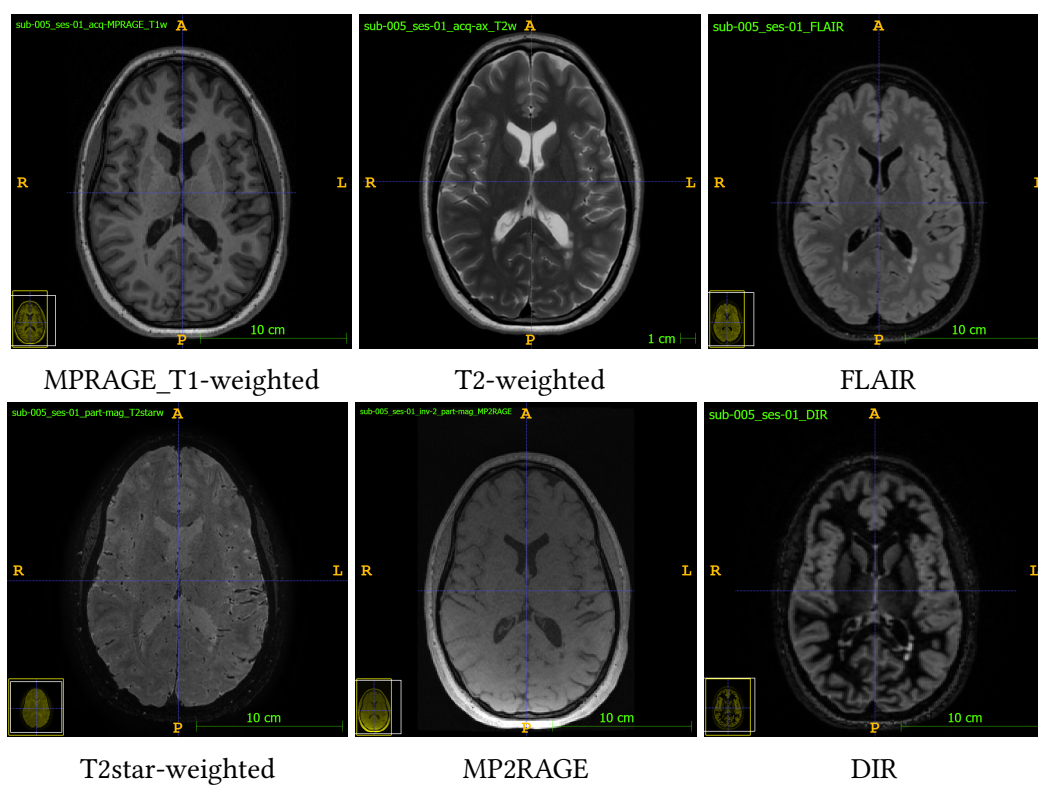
All acquired MRI images
